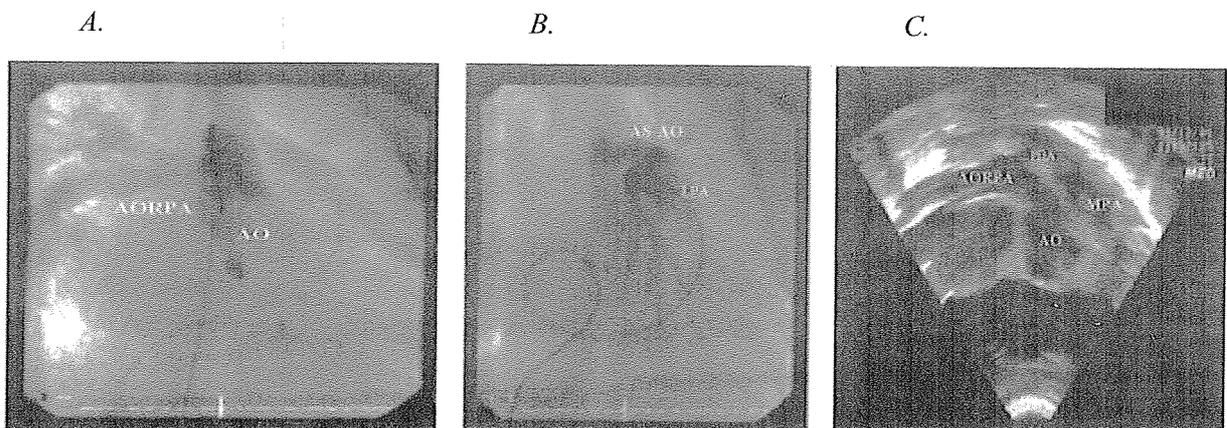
Preoperative examinations' data in patient 7 - A. Anomalous origin of the right pulmonary artery from the ascending aorta. B. The origin of the left pulmonary artery from the main pulmonary artery trunk and the visualization of the ascending aorta through the patent ductus arteriosus. C. Echocardiographic examination showing the anomalous origin of the right pulmonary and the presence of ductus arteriosus; and in patient 8 - D. Anomalous origin of the right pulmonary artery from the right lateral aspect of the ascending aorta. E. The origin of the left pulmonary artery from the main pulmonary artery trunk.
